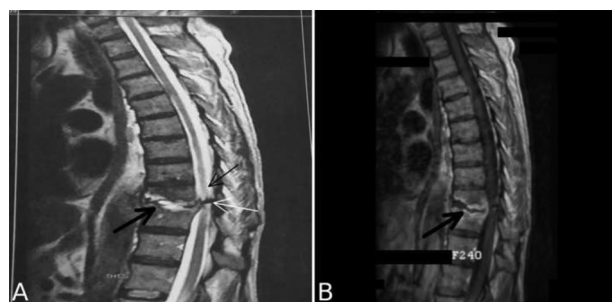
a) MRI T2 sequence of the thoracic spine, showing high spinal cord signal in the T9-T10 level suggestive of myelopathy (thin black arrow) and subsidence of the T10 vertebral body due to spondylodiscitis (thick black arrow). Also note a bony fragment causing spinal cord compression and obstruction of CSF flow, leading to raised CSF protein levels (white arrow). b) T1 post Gd+ showing gadolinium enhancement and destruction of the T10 vertebral body (black arrow).
